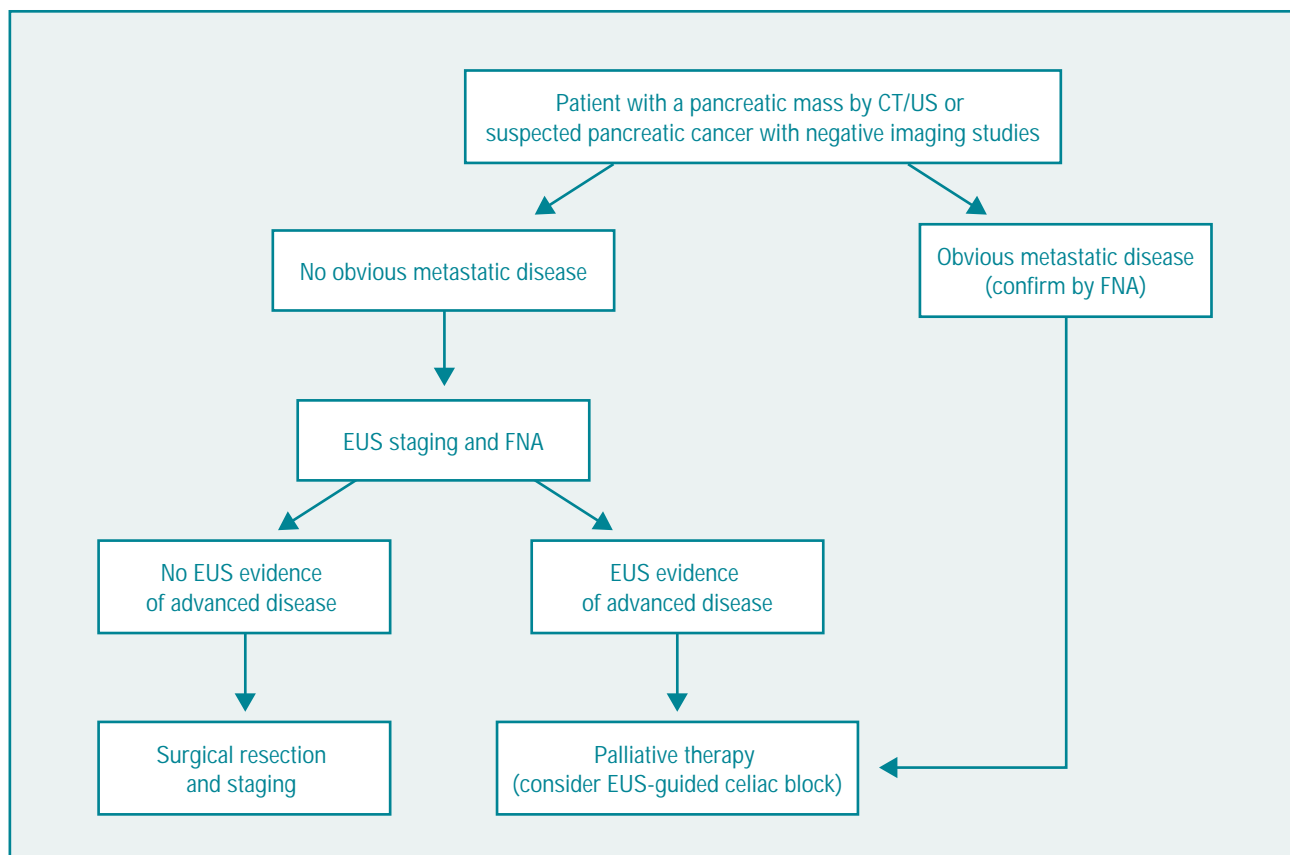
Suggested algorithm for pancreatic cancer staging for a patient with a pancreatic mass by CT/US or suspected pancreatic cancer with negative imaging studies.
